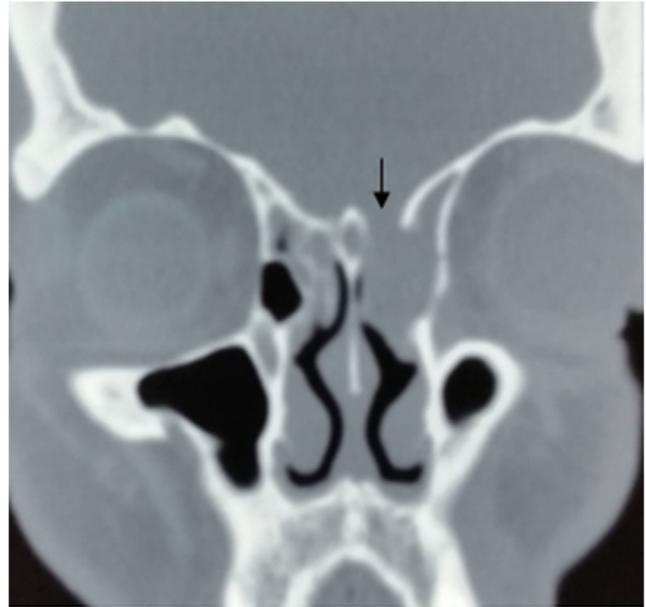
CT scan of the head (coronal view)
